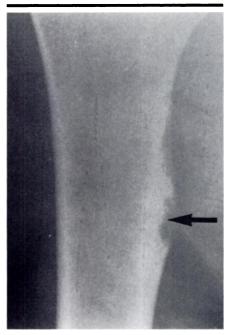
Juxtacortical chondroma. Anteroposterior radiograph of the proximal humerus shows benign-appearing cortical thickening with a central elongated radiolucency (arrow).
